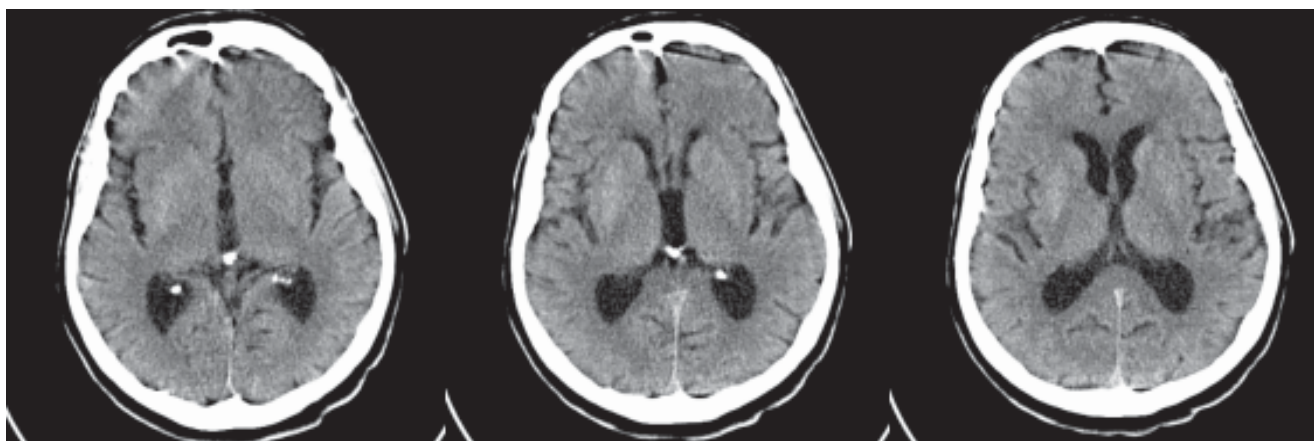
CT brain scan showing mild hyperdensity of the right striatum
